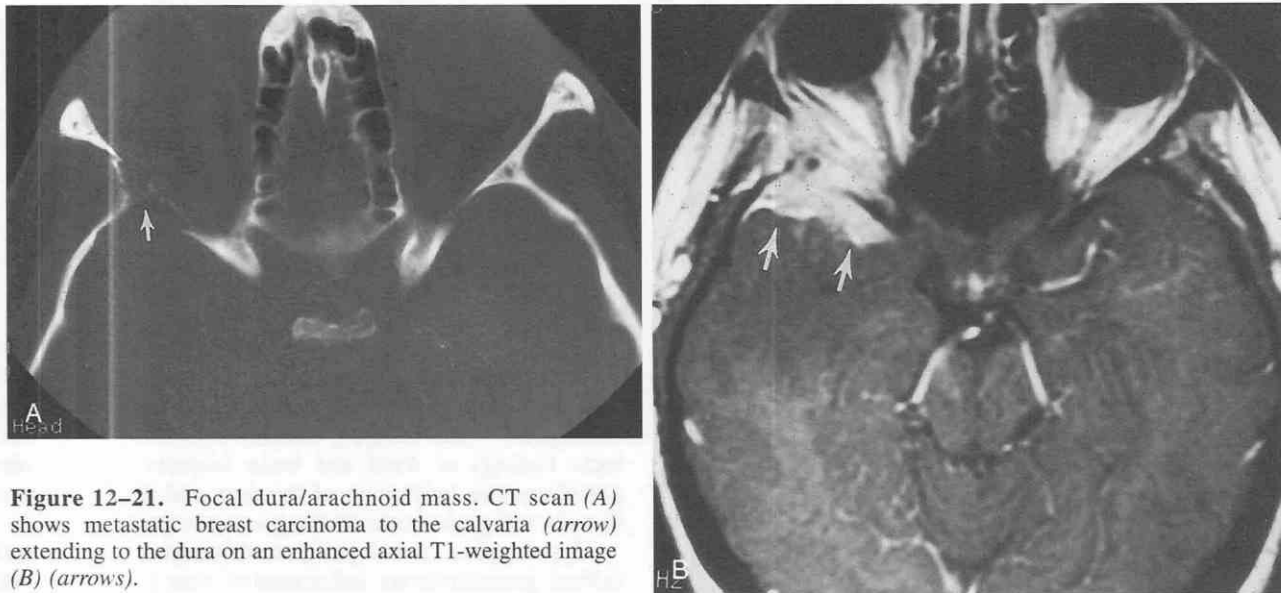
Focal dura/arachnoid mass. CT scan (A) shows metastatic breast carcinoma to the calvaria (arrow) extending to the dura on an enhanced axial T1-weighted image (B) (arrows).
